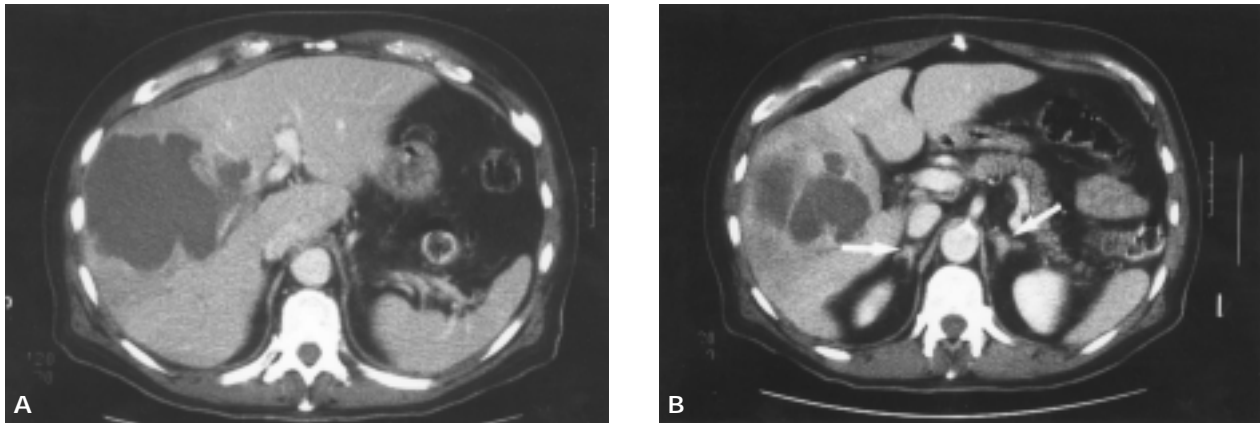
Computed tomography of the patient's abdomen with intravenous contrast at initial presentation shows (A) amebic abscess in the right lobe of the liver and (B) both adrenal glands, which are normal (*arrows*).
